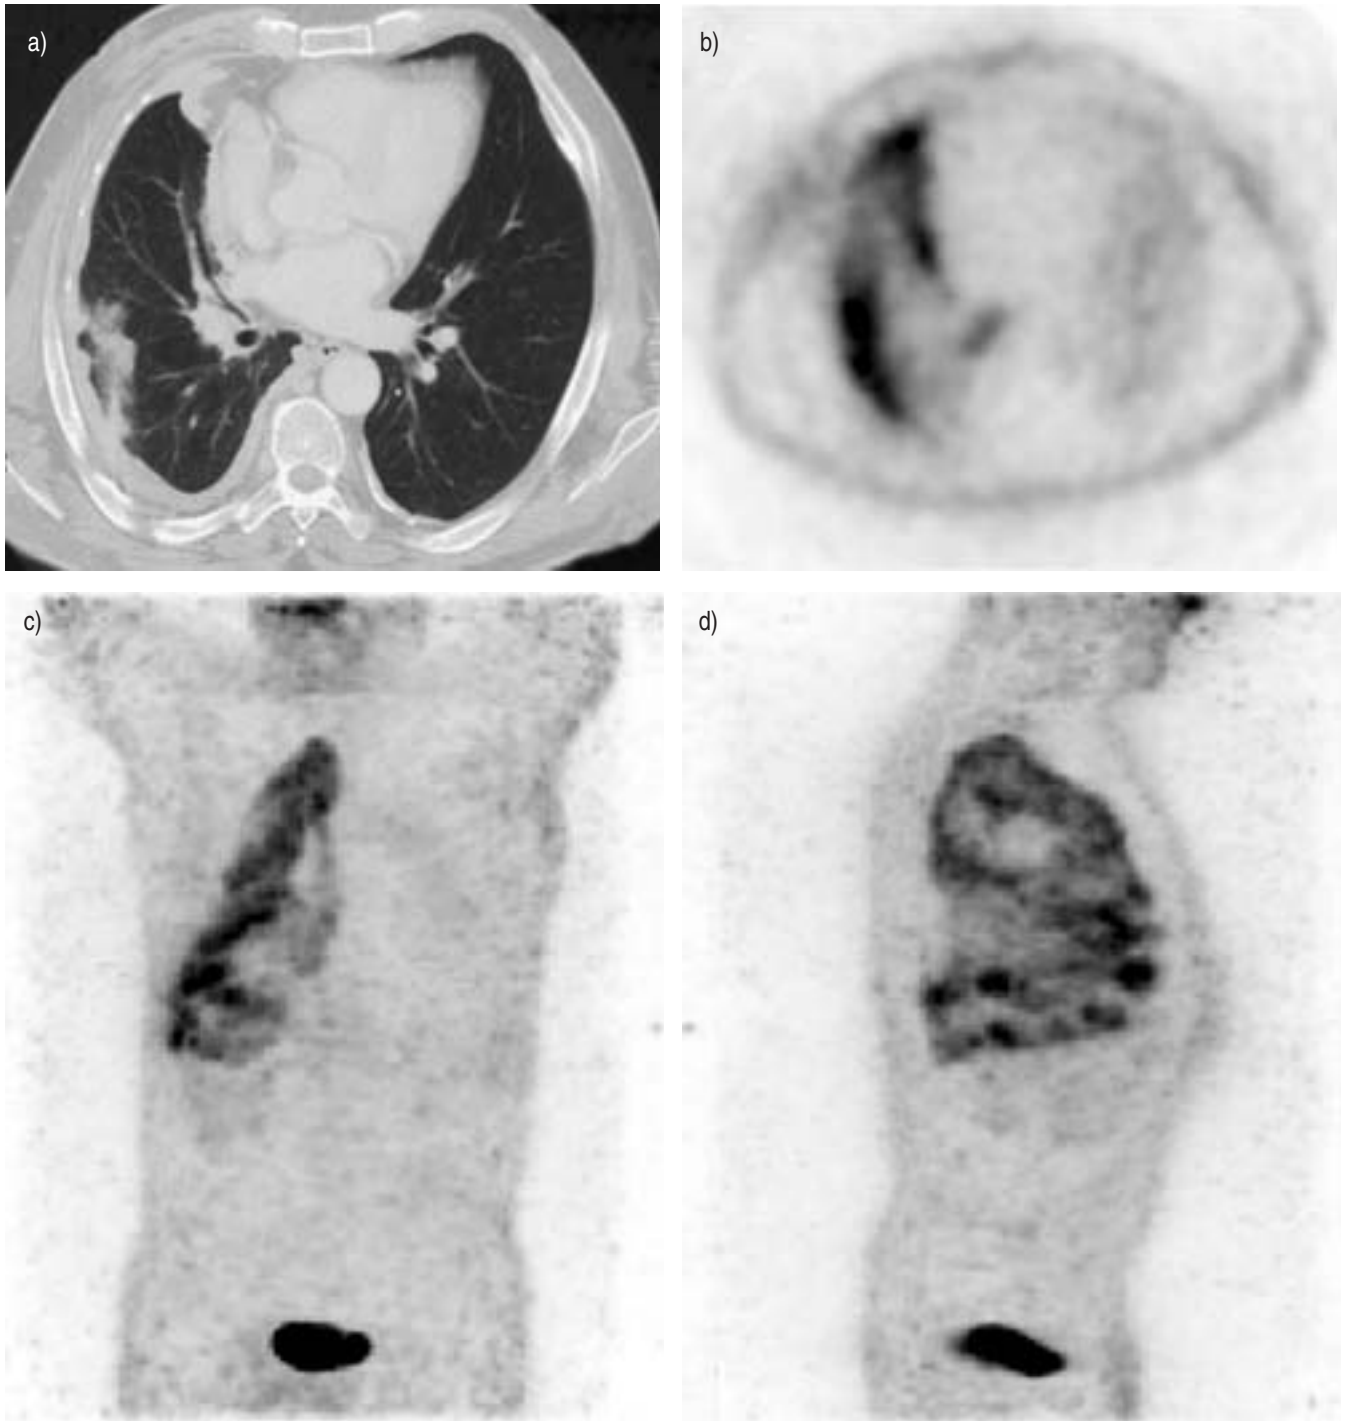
A 60-yr-old patient with epithelial mesothelioma. a) Transverse computed tomography scan slice showed right pleural thickening. b) Transverse ^{18}F -fluorodeoxyglucose (^{18}F FDG) imaging *via* coincidence detection emission tomography slices revealed extensive pleural involvement of pleural surfaces. Three-dimensional imaging in maximum pixel raytrace in the anterior (c) and right lateral (d) views confirmed diffuse ^{18}F FDG uptake surrounding the right hemithorax.
